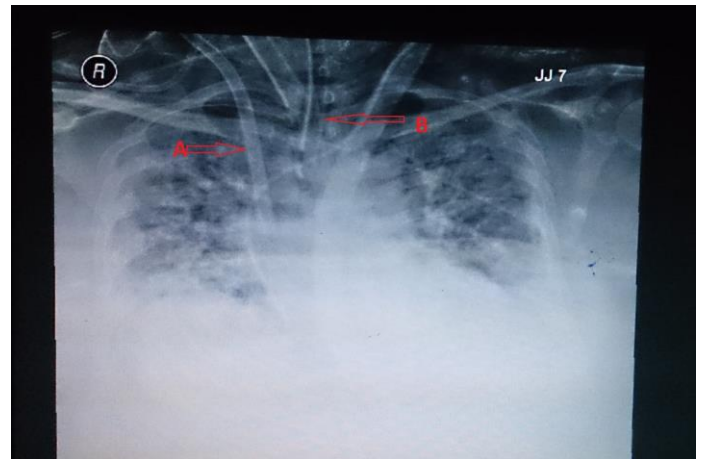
Chest X-ray showing B/L infiltrates involving all the four quadrants of the lungs; A-ECMO cannula in Right IJV; B-Endotracheal tube in situ
